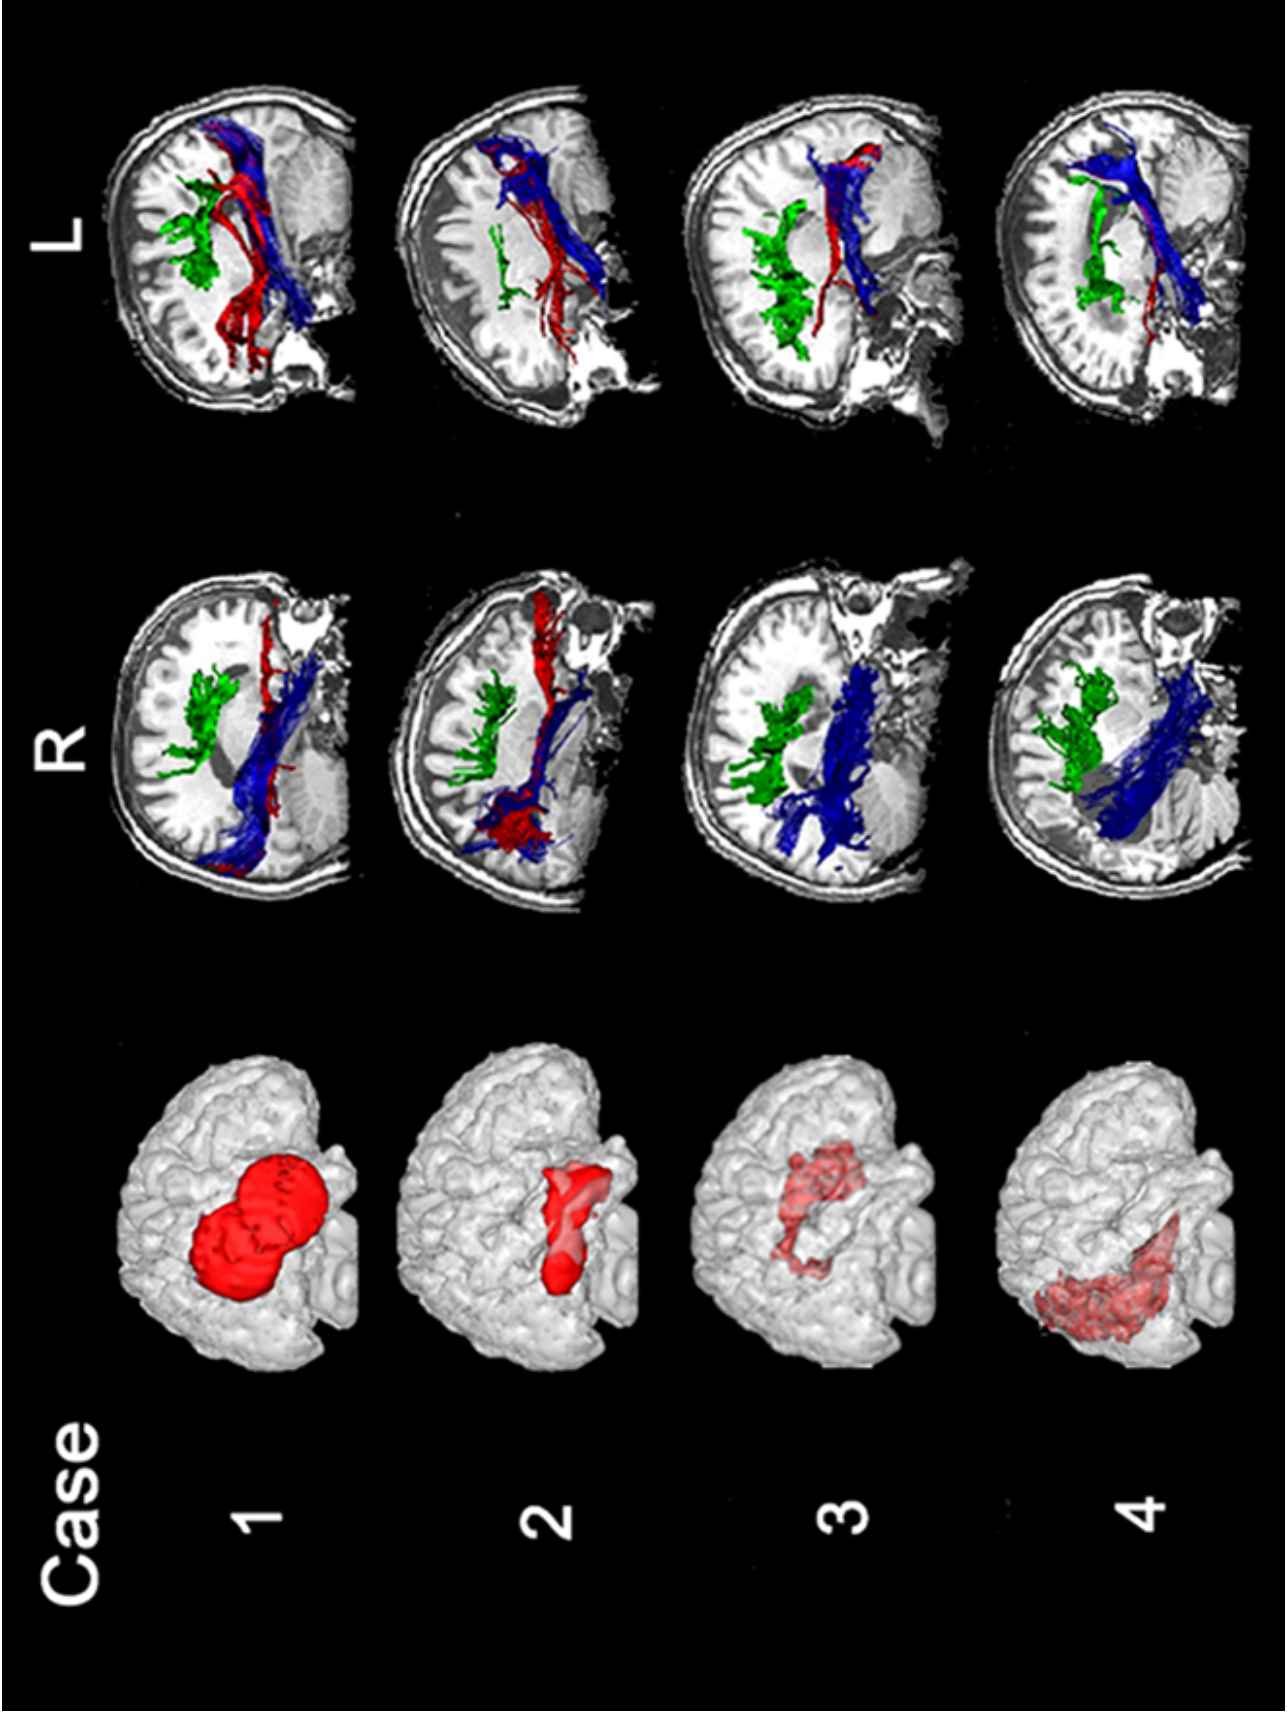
Three-dimensional anatomical reconstruction of the patients' lesions and lateral views (right hemisphere, R; left hemisphere, L) of the DTI tractography of the SLF (in green), the ILF (in blue) and the IFOF (in red) for the four patients studied. For each hemisphere, the three fasciculi are displayed on a T1 sagittal native MRI slice in the anterior/posterior commissure referential.
